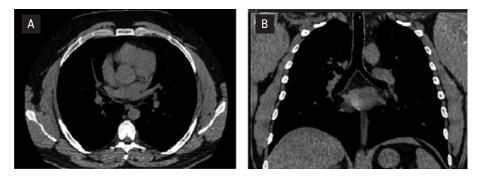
Computed tomography (CT) scans showing normal mediastinal lymph nodes before laparoscopic adrenalectomy.* A. *Transverse plane;* B. *Coronal plane*
